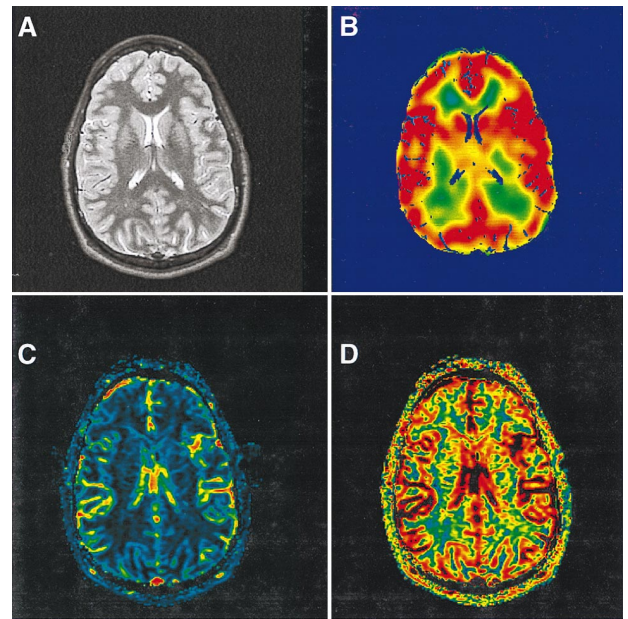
Representative images of co-registered MRI (A), SPECT (B), and perfusion MRI without (C) and with (D) elimination of large vessels from a healthy volunteer. The slice shown is located at the level of the basal ganglia, internal capsule and thalamus. The color scale used to display perfusion ranges from blue (lowest) through yellow and orange to red (highest).
